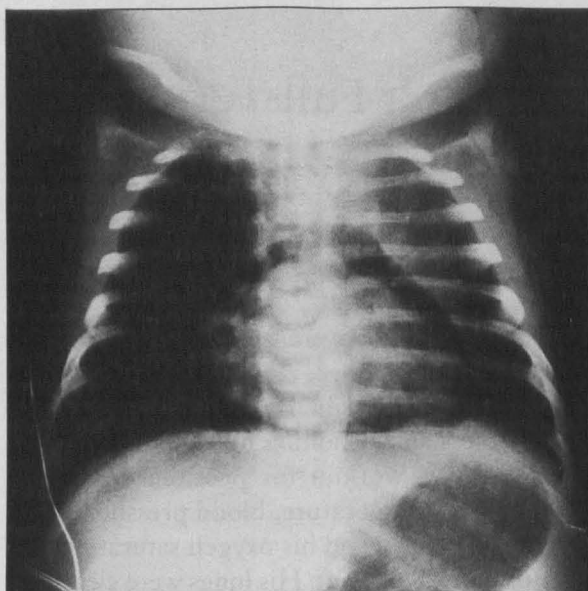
Initial anteroposterior chest radiograph showing the classic pneumopericardial halo sign.
